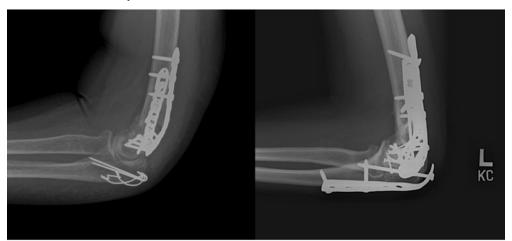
Post-operative radiographs following distal humerus ORIF with olecranon osteotomy fixed with TBW (left) and PF (right).
